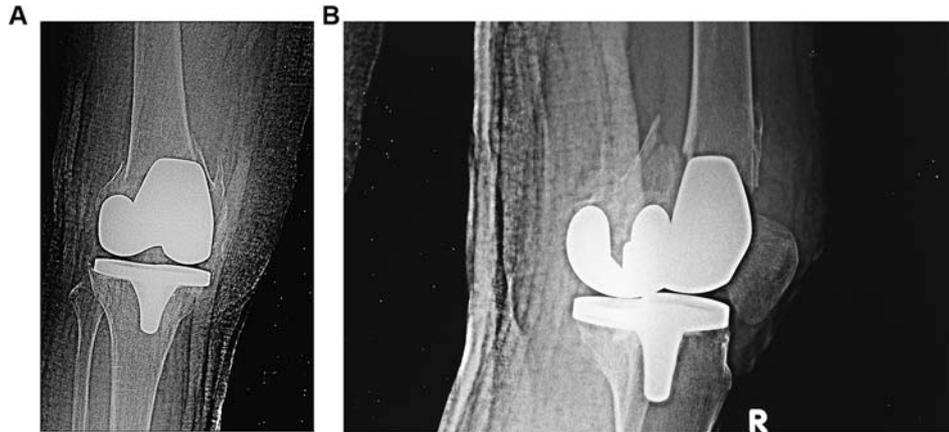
A and B: Preoperative anterior posterior and lateral knee radiographs showing the course of the fracture line extending to the distal of the prosthesis
